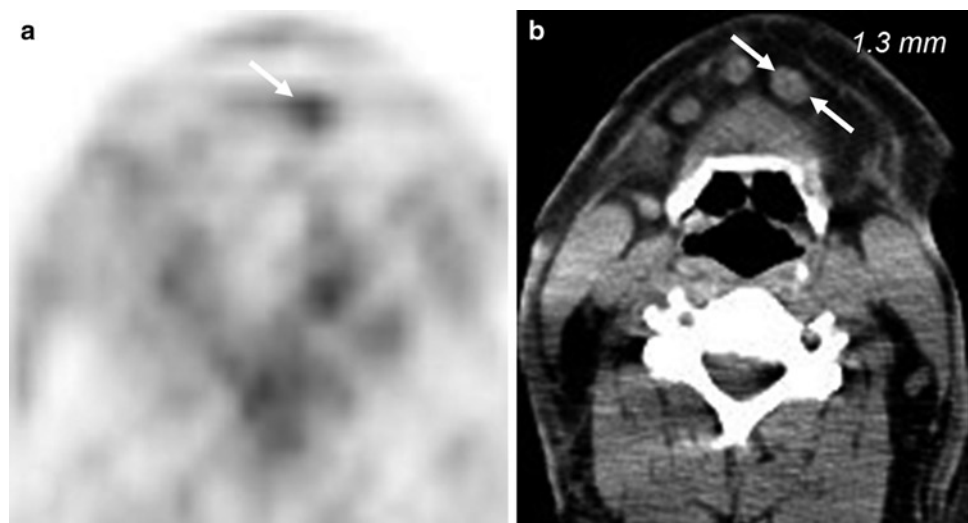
Mantle cell lymphoma showing FDG avidity (a) in a nonenlarged left level 1 lymph node (arrows) in the neck (b)
